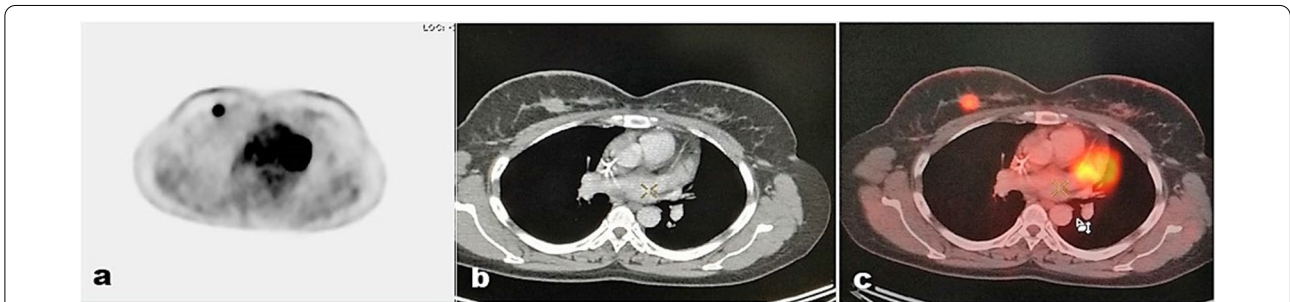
35 years old patient with recently diagnosed right sided luminal A breast carcinoma. TLR= 2.17, TSR= 2.7. a Trans axial PET image with corresponding CT axial cut in b showing a speculated isodense enhancing soft tissue mass at the upper quadrant of the right breast. It measures about 5.2 × 2.5 cm. b Fused PET/CT axial cut shows that the lesion is FDG avid displaying SUV_{max} ~4.35
